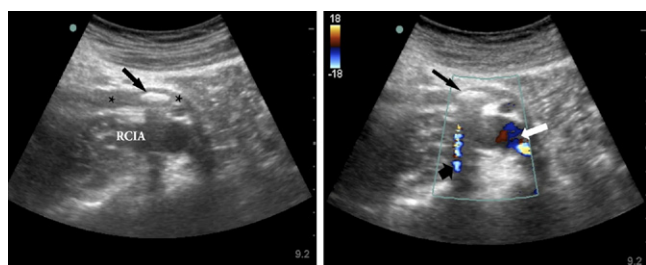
B-mode ultrasonography (left) shows a large stone (black arrow) within the dilated ureter, with shadowing over the right common iliac artery (RCIA). The same structures are visualized with duplex color Doppler (right). A comet tail-shaped twinkling artifact (thick black arrow) is shown running with the stone shadow and posterior to the RCIA (white arrow). These images were obtained with the transducer placed over the right lower abdomen.
